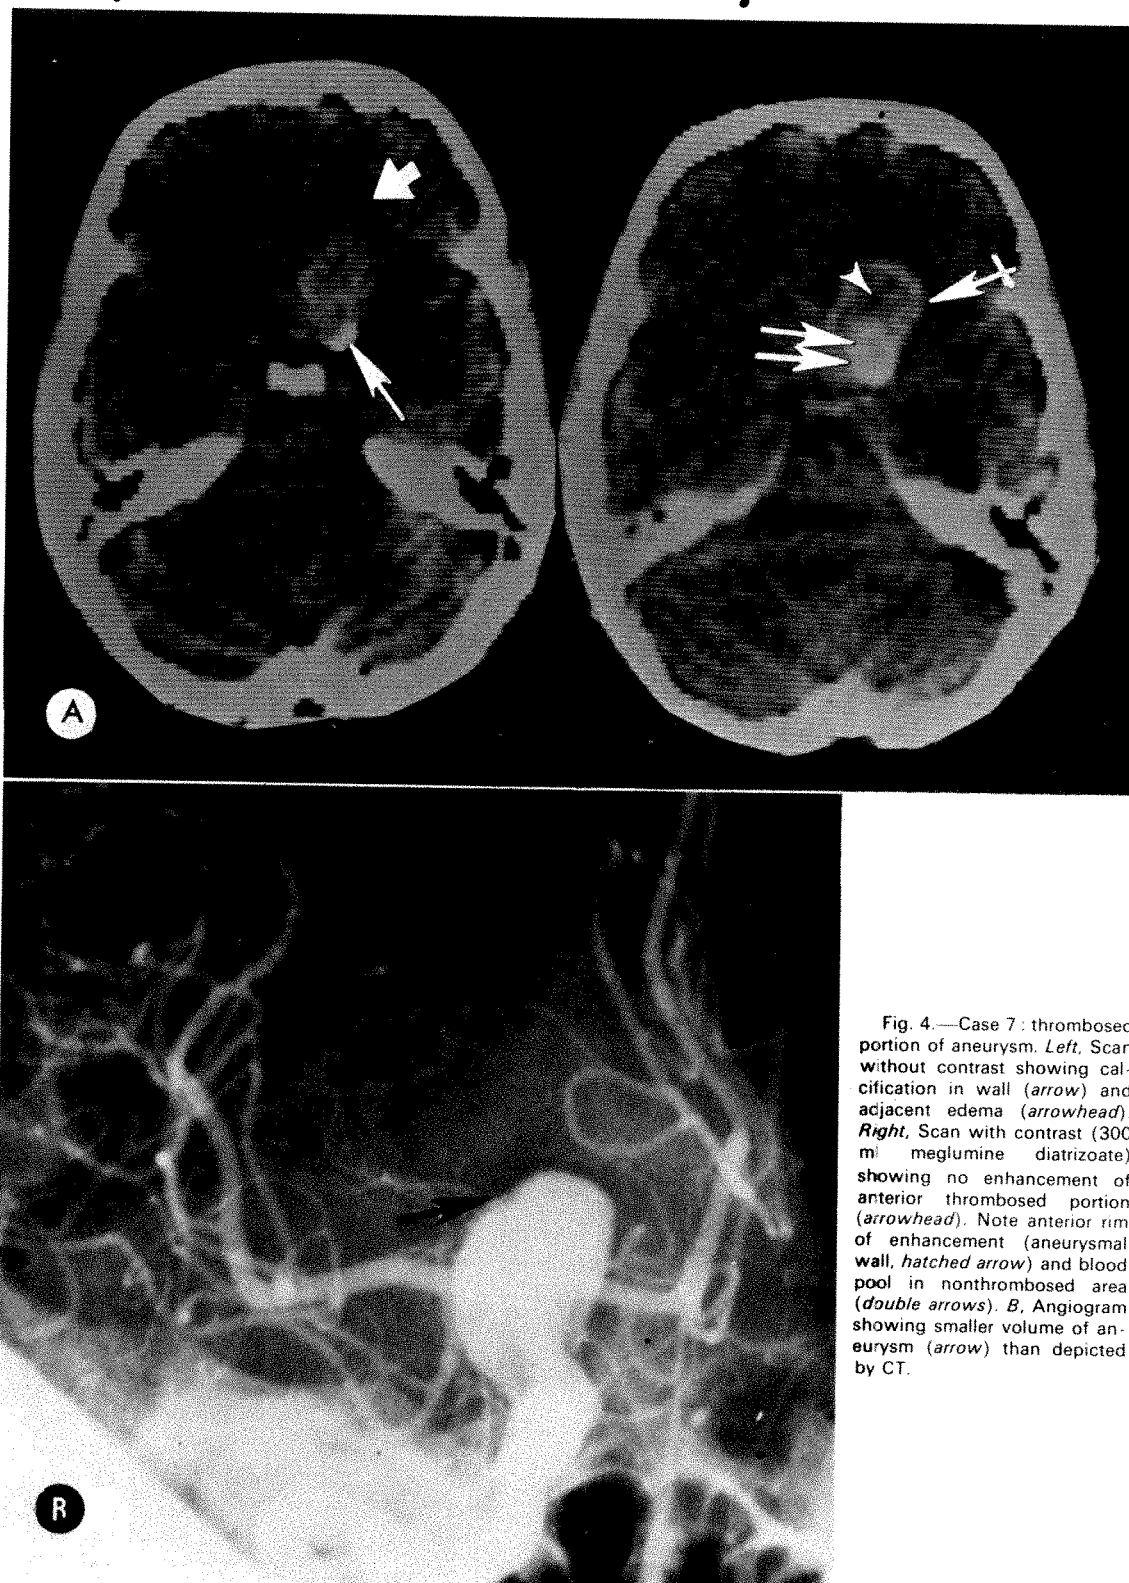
Case 7: thrombosed portion of aneurysm. *Left*, Scan without contrast showing calcification in wall (arrow) and adjacent edema (arrowhead). *Right*, Scan with contrast (300 ml meglumine diatrizoate) showing no enhancement of anterior thrombosed portion (arrowhead). Note anterior rim of enhancement (aneurysmal wall, hatched arrow) and blood pool in nonthrombosed area (double arrows). *B*, Angiogram showing smaller volume of aneurysm (arrow) than depicted by CT.
